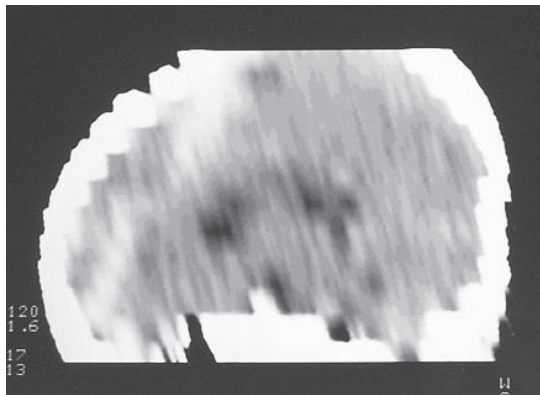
CT (sagittal reconstruction) showing ISDH in the falx
